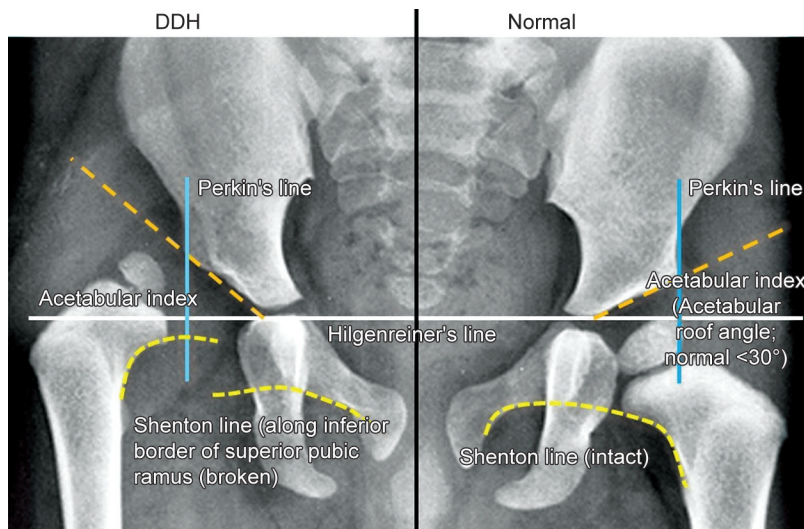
X-ray of a young infant with DDH. The image lines are as described in the adjoining text in the article
